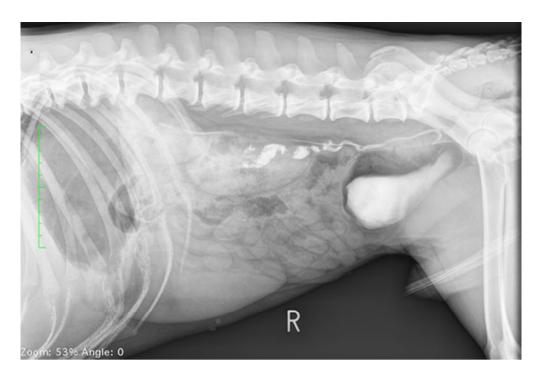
Intravenous urography right lateral radiograph: A highly irregular ureter is visible, extending from the level just distal to the renal pelvis to the level of cranial L6. The distal third of the ureter is visualised more clearly than on the VD. It is very mildly thickened, but there are no irregularities of the wall, or filling defects seen.
